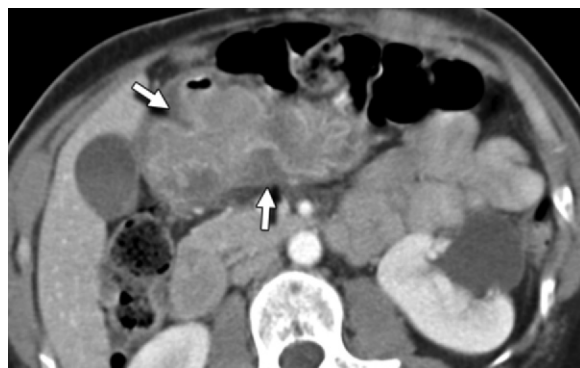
Gastritis in a patient who presented to the emergency department with abdominal pain and vomiting. Axial postcontrast CT image demonstrates diffuse gastric wall thickening and fold thickening with low attenuation of the gastric wall and mucosal enhancement (arrows).
